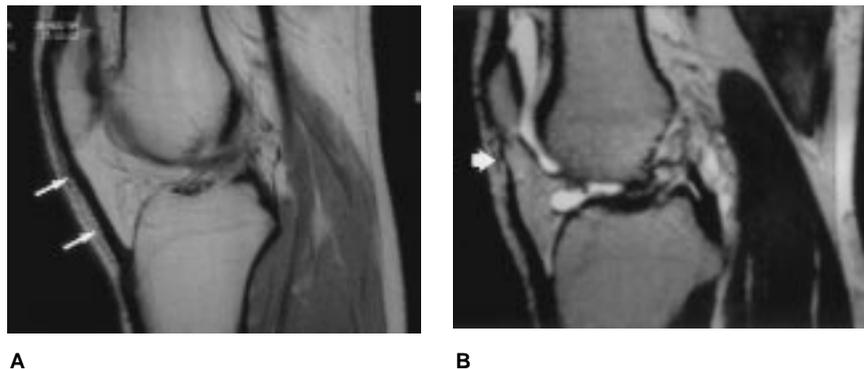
A, Sagittal proton-density MR image of a normal patellar tendon (arrows). B, Sagittal T2-weighted MR image of a subacute partial proximal patellar tendon rupture (arrow). Note the attenuated proximal tendon and lack of hematoma, which is indicative of a subacute injury.
